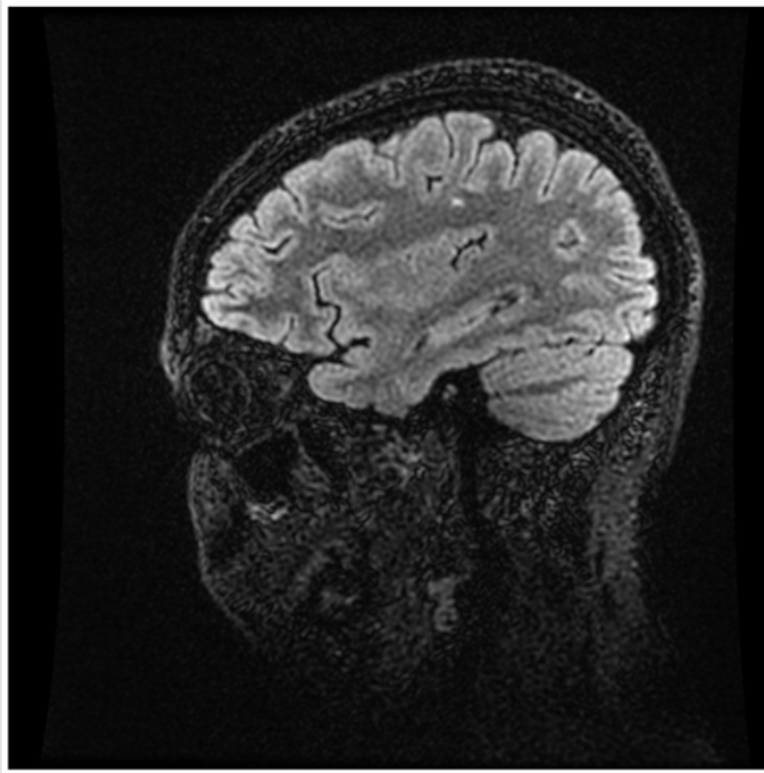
MRI head and neck with contrast showing supratentorial demyelinating lesions.
